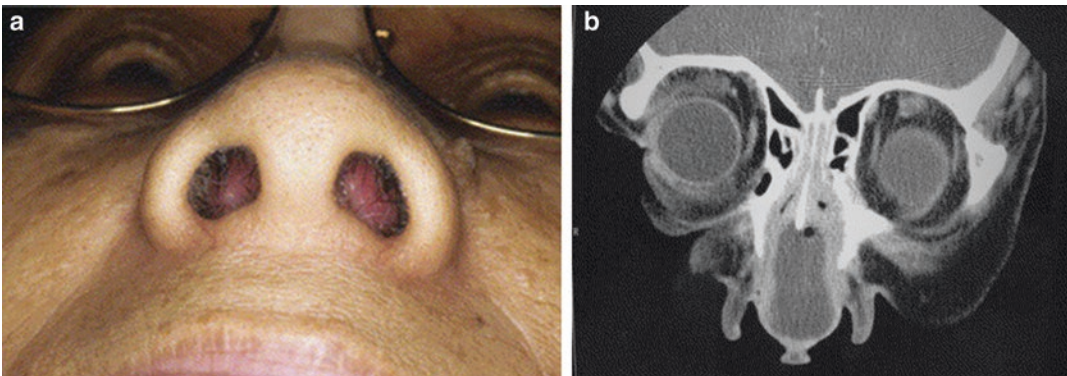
(a, b) Nasal septal abscess. A 69-year-old woman presented with 4 days of nasal obstruction and pain. (a) Examination showed bilateral septal swelling causing obstruction. (b) Coronal computed tomography (CT) showed septal abscess with gas bubble. Surgical
